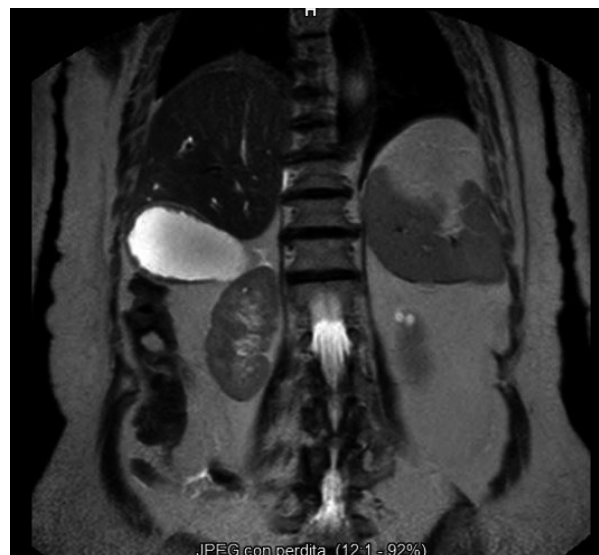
Magnetic resonance image.
